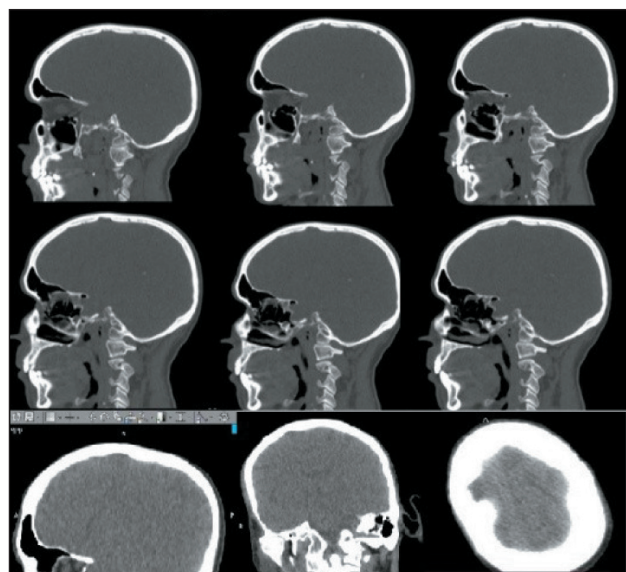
There is sclerotic changes like lesion on vertex of skull bone of CT scan of brain. Note: created by the authors
